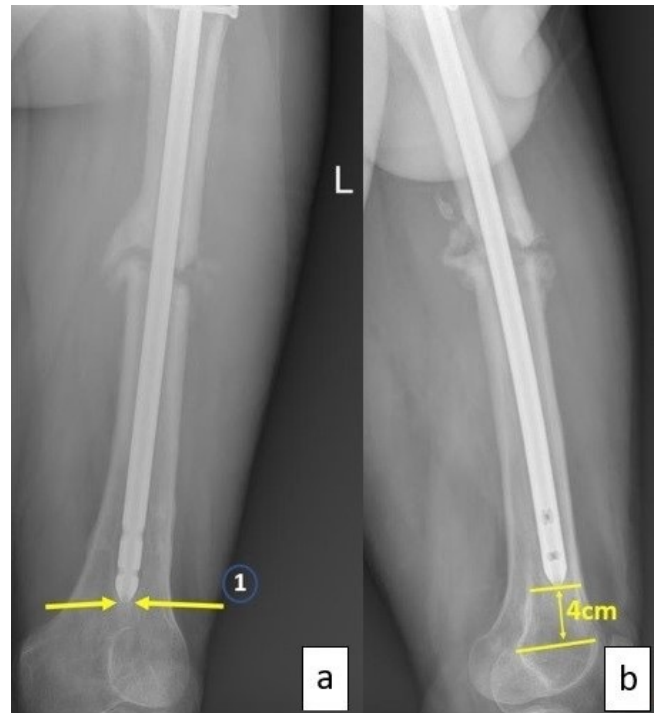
a-preoperative A/P radiograph showing nail tip sclerosis; b-preoperative distance of distal nail tip to the joint (4 cm).
